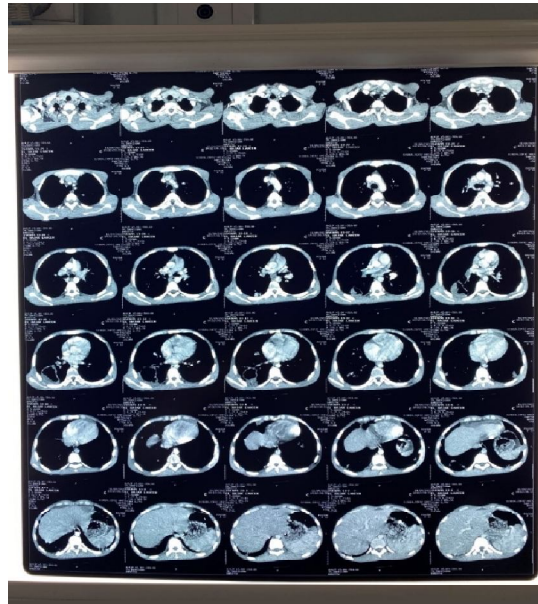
CT Thoracic angiogram showing intra-RV mass
